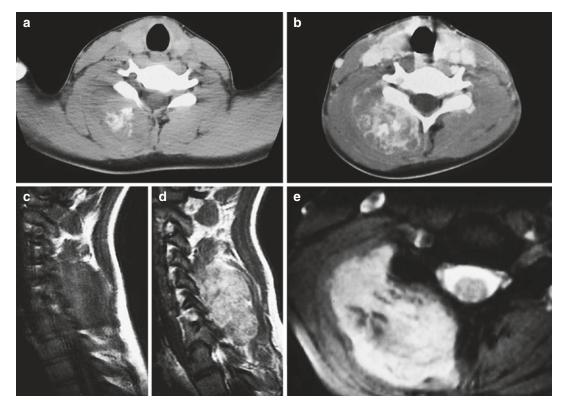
pPNET of the lower neck in a 12-year-old girl. (a) CT. (b) CT after iodinated contrast injection. (c) Sagittal spin-echo T1-weighted MR image. (d) Sagittal spin-echo, contrast-enhanced T1-weighted MR image. (e) Axial gradient-echo T2-weighted MR image. Large mass within the deep cervical muscles on the right side of the neck. The tumor contains irregular calcifications (a). There is marked enhancement after contrast injection (b).
